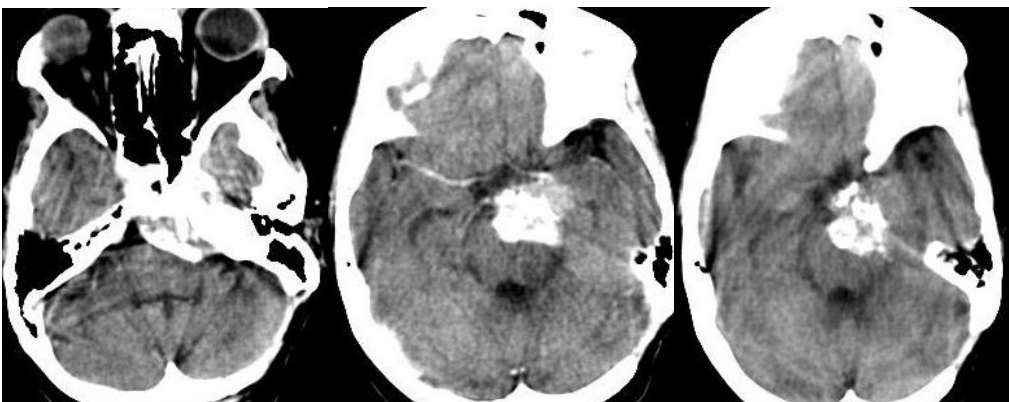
showing axial contrast CT scans of the same patient 7 years postop. The residual tumour size has decreased and there is dense calcification seen within
